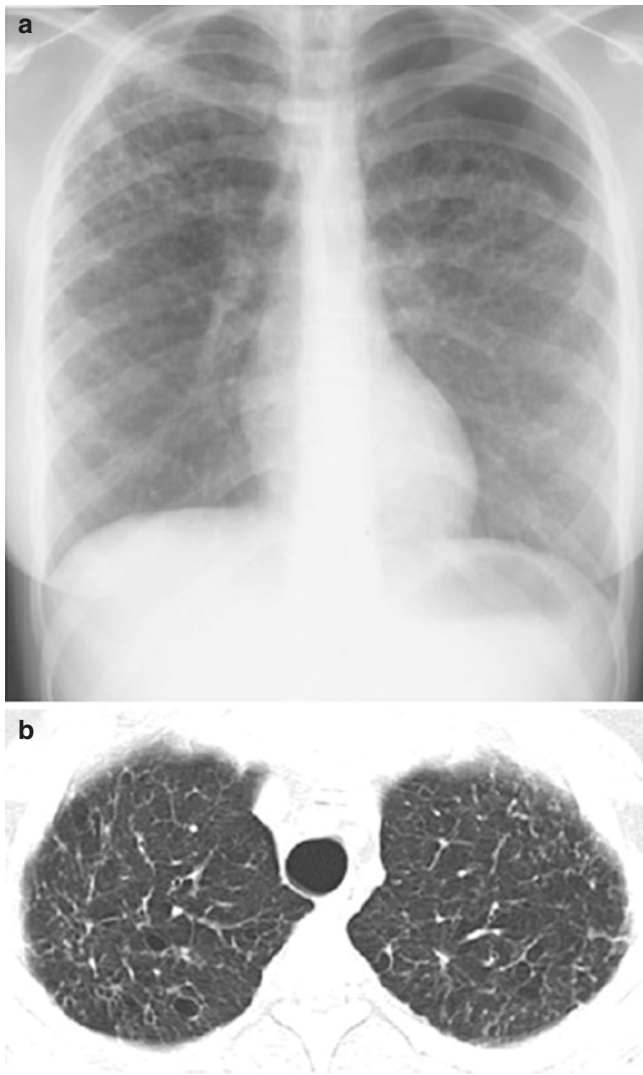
(a) Chronic Langerhans cell histiocytosis (LCH): there is coarse ILD with multiple cysts, dominantly in the upper lobes. There is a left pneumothorax. (b) Chronic LCH: Axial lung window CT image reveals honeycombing with peripheral cysts and intralobular septal thickening
